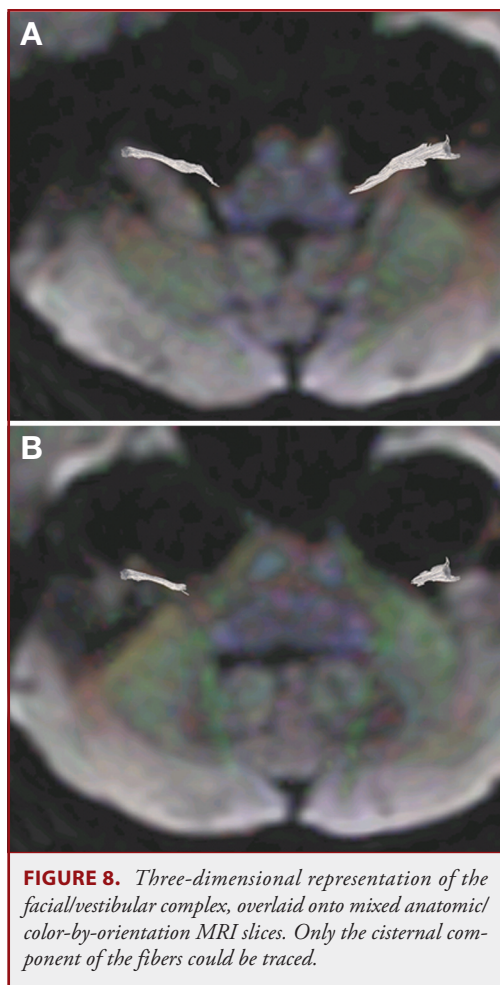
Three-dimensional representation of the facial/vestibular complex, overlaid onto mixed anatomic color-by-orientation MRI slices. Only the cisternal component of the fibers could be traced.
